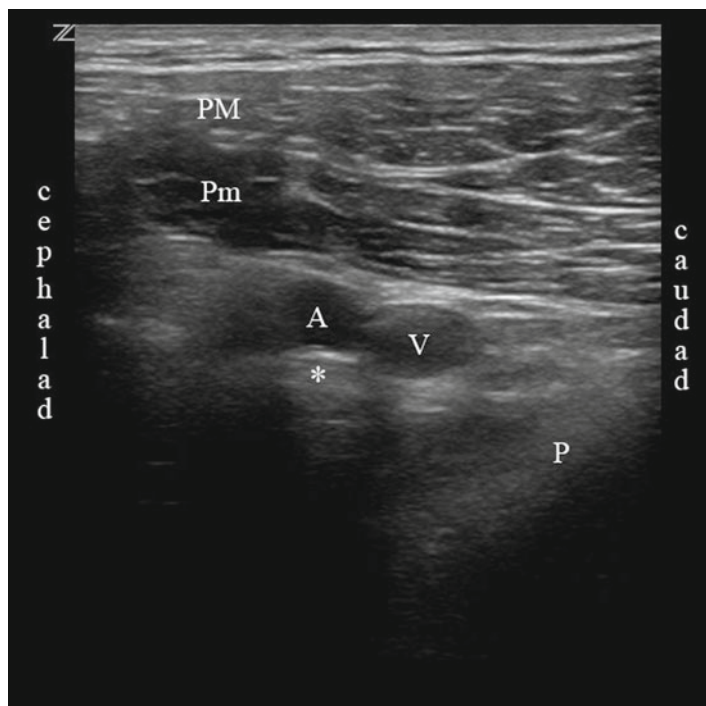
Ultrasonographic appearance of the infraclavicular brachial plexus (A axillary artery, P pleura, PM pectoralis major muscle, Pm pectoralis minor muscle, V axillary vein, asterisk indicates target)
